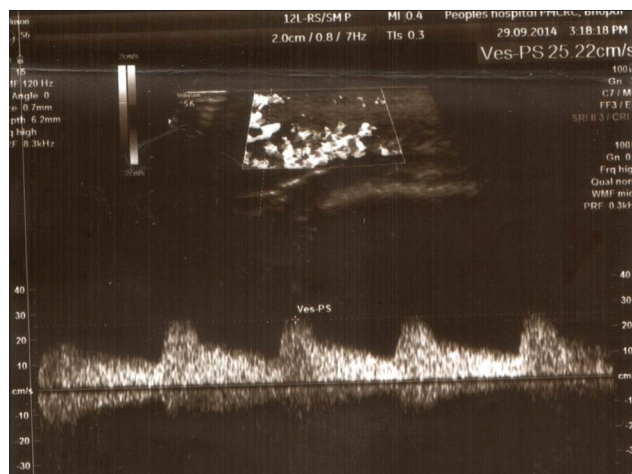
Ultrasonogram of the lower lip showing a high peak systolic volume
